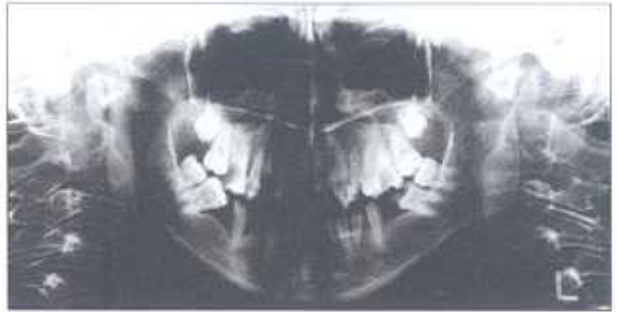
Panoramic radiograph showing the pulp stone of the maxillary right second molar.
